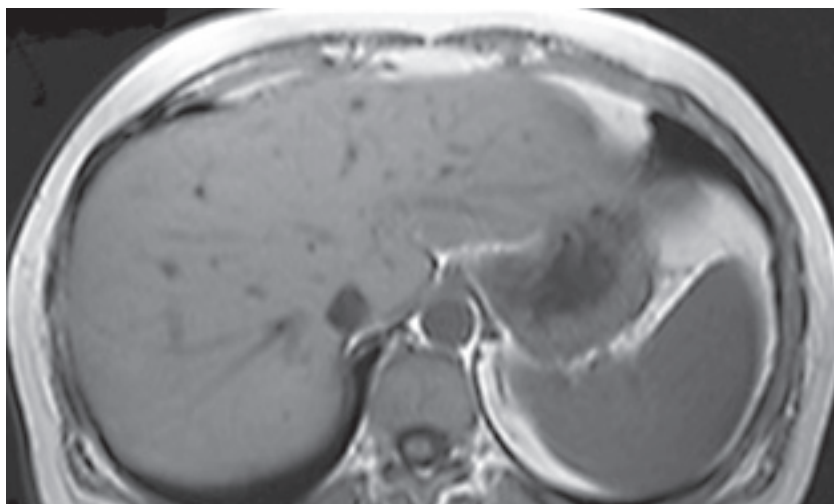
Follow-up MRI scan of abdomen following completion of antimicrobial therapy showing resolution of the abscess.
